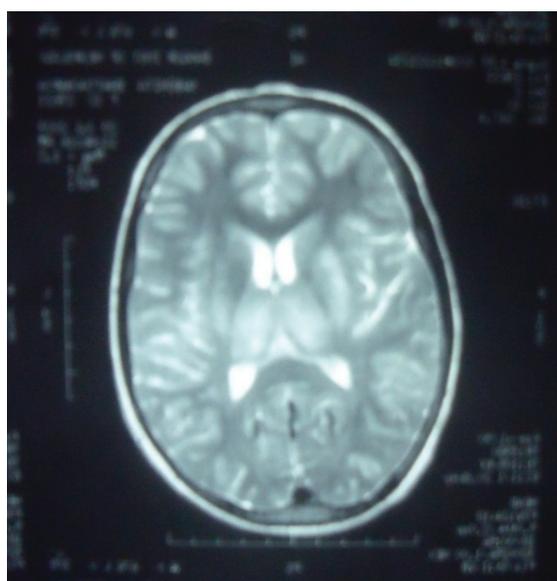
T2-weighted brain MRI showing bilateral symmetrical hyperintensities in the basal ganglia and thalamus
